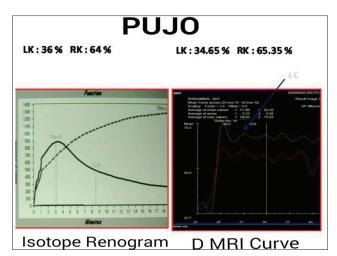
Isotope renogram and dynamic magnetic resonance imaging curves in pelviureteric junction obstruction
